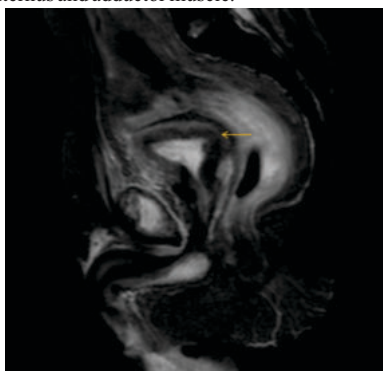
MRI T2 fat saturation sagittal section shows thickened urinary bladder wall with thickness of ~ 10mm with surrounding hyperintensity.
